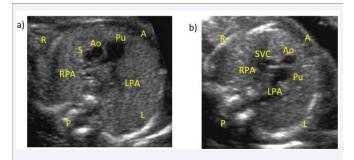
a) Two-dimensional echocardiographic image of the three-vessel view in the fetus of case one showing normal arrangement of the great vessels in posterior TGA. The aorta (Ao) is posterior to the pulmonary artery (Pu) as is seen usually in fetuses with normally related great vessels. In comparison b) shows the abnormal arrangement of the vessels in the three-vessel view in a usual case of TGA, with the aorta anterior and rightward of the pulmonary artery. A = anterior, P = posterior, R = right, L = left, S = superior vena cava, Ao = aorta, Pu = pulmonary artery, RPA = right pulmonary artery, LPA = left pulmonary artery.
